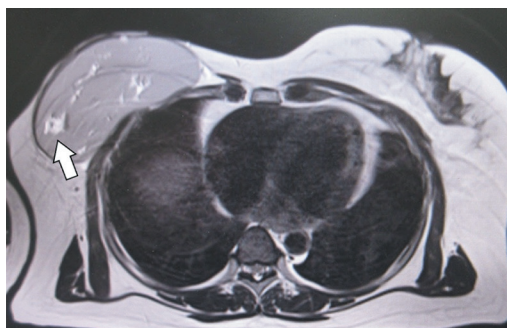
Case with actual breast implant fracture. Magnetic resonance imaging showing hyperintense changes inside the implant, similar to case 1 (arrow).
